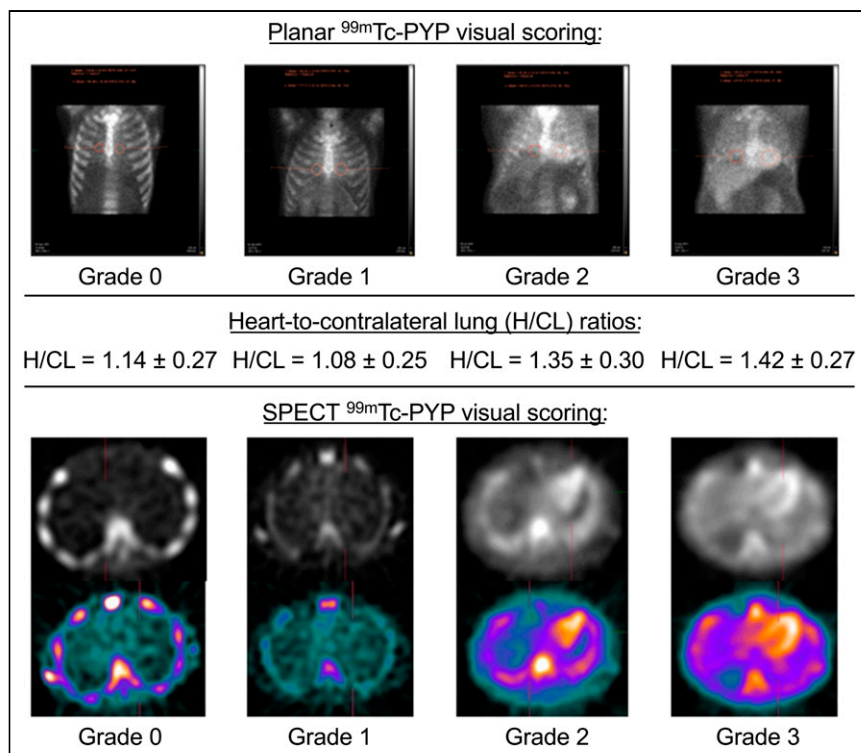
Cardiac amyloidosis ^{99m}Tc -pyrophosphate semiquantitative and quantitative interpretation. (Top) Planar 3-h images demonstrating diffuse myocardial uptake and grade based on comparison of ^{99m}Tc -pyrophosphate myocardial uptake with rib. (Middle) H/CL ratio. (Bottom) Gray-scale and color SPECT images confirming myocardial uptake. PYP = pyrophosphate.
